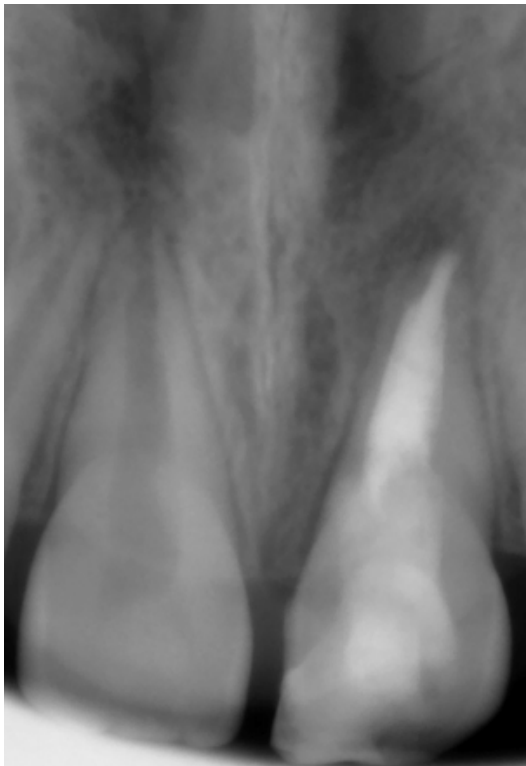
Control x-ray after root canal treatment
